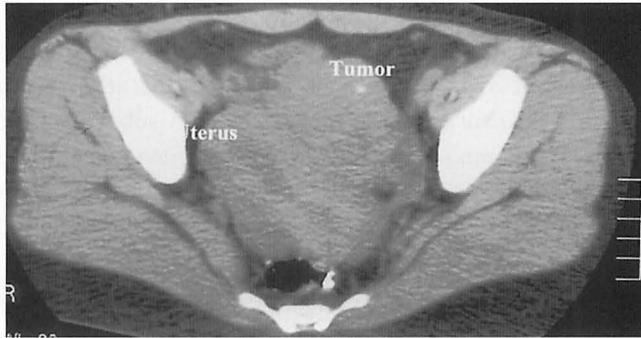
CT of case 2 revealed pelvic mass, 8×5 cm in size. The tumor being adjacent to the uterus gave an impression of uterine leiomyoma.
